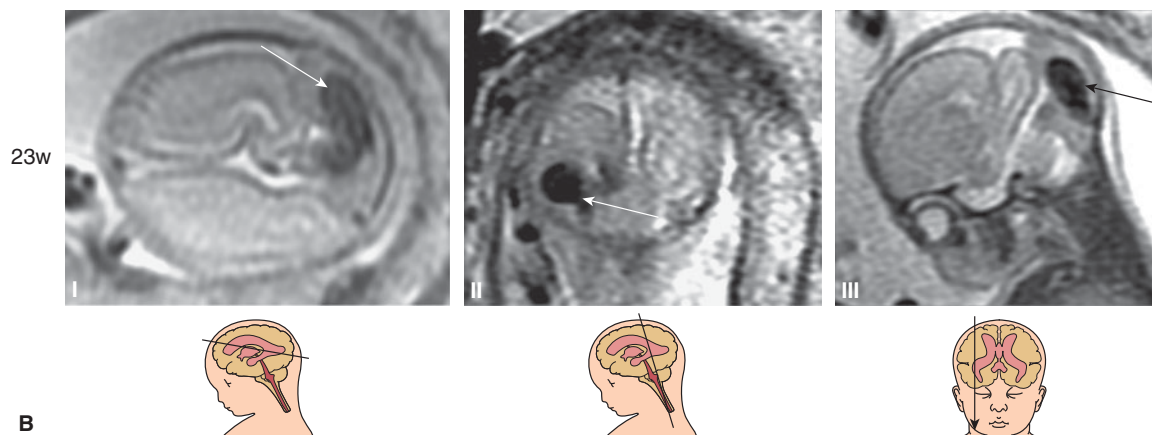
(continued) (B) MRI images of the patient with thrombosis of the lateral sinus at 23 postmenstrual weeks. (I) Axial plane through the thrombus (arrow). (II) Posterior coronal plane. (III) Parasagittal plane across the thrombus (arrow). (Courtesy of Caterina Montull, Barcelona, MD, Spain.)
